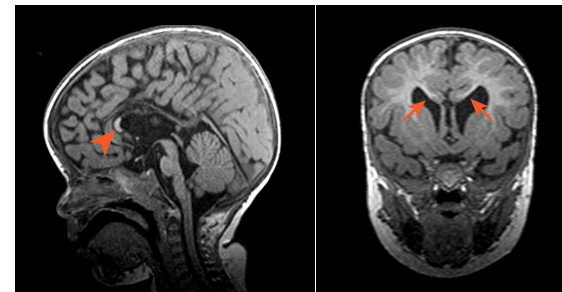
Sagittal and coronal T1-weighted images of the proband at 13 months of age, depicting partial agenesis of the corpus callosum with only the genu present (arrowhead) and the presence of Probst bundles (arrows).
